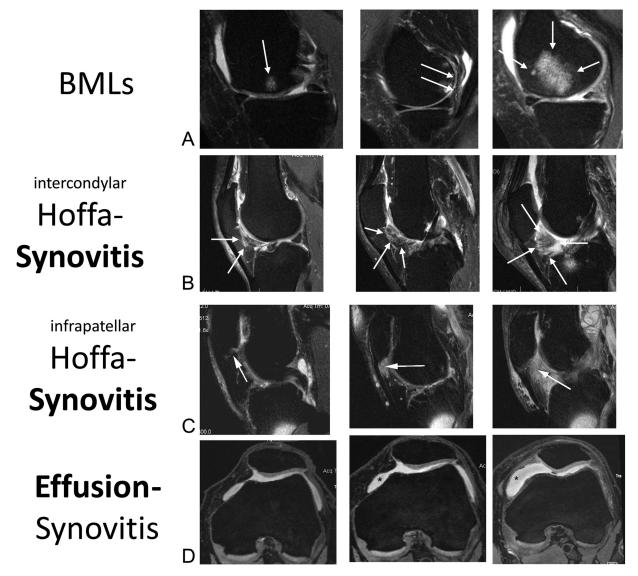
Examples of magnetic resonance imaging (MRI) lesion grading. A, Bone marrow lesions (BMLs). B and C, Hoffa-synovitis in the intercondylar (B) and infrapatellar (C) regions. D, Effusion-synovitis on non–contrast-enhanced MRI. Note that BMLs were assessed on a persubregion basis, summing all BMLs in the subregion with regard to the percent involved, while Hoffa-synovitis and effusion-synovitis were assessed on a per-knee basis. The left column shows grade 1 lesions, the middle column shows grade 2 lesions, and the right column shows grade 3 lesions. Arrows indicate synovitis; asterisks indicate effusion.
